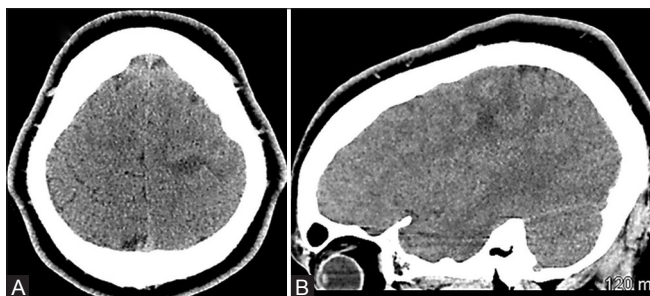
(A and B): Axial (A) and sagittal (B) unenhanced CT head done in case 1 shows ill-defined hyperdense ring configuration lesion in the left frontoparietal region with surrounding vasogenic edema
